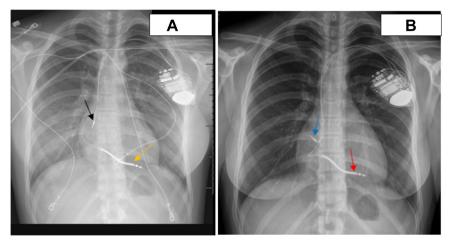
A: Initial chest radiograph performed after implantable cardioverter-defibrillator implantation showing defibrillator lead in right ventricle (*yellow arrow*) and pacing lead in right atrium (*black arrow*). B: Chest radiograph performed upon presentation to the emergency department showing defibrillator lead in right ventricle (*red arrow*) and pacing lead in right atrium (*blue arrow*).
